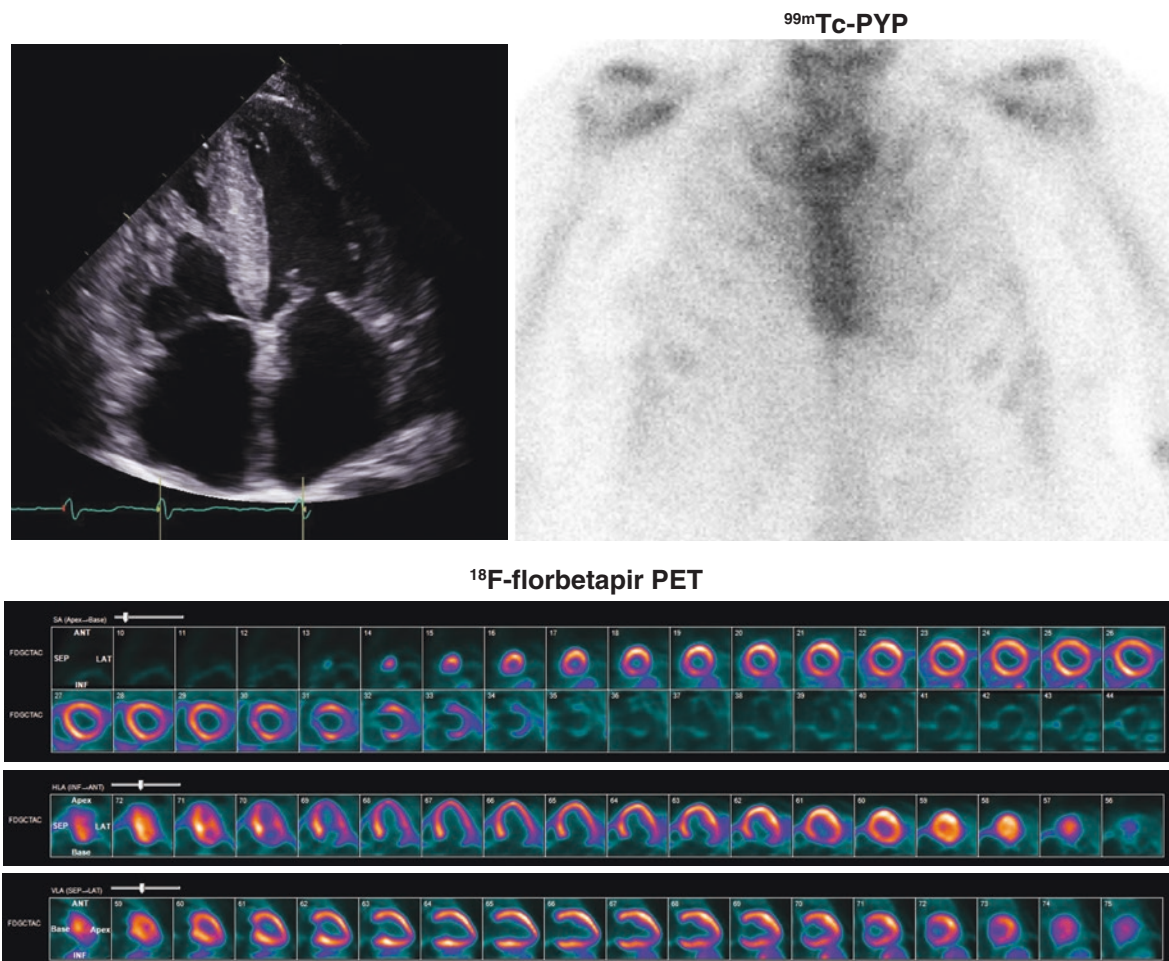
^{99m}Tc -PYP images in a patient with AL cardiac amyloidosis. In this 62-year-old African American man with a V122I TTR mutation, the echocardiographic (*top left panel*) and CMR imaging was consistent with cardiac amyloidosis, but the ^{99m}Tc -PYP scan (*top left panel*) was negative (grade 1), excluding ATTR cardiac amyloidosis. A complete hematological evaluation (serum free light chain levels, serum
